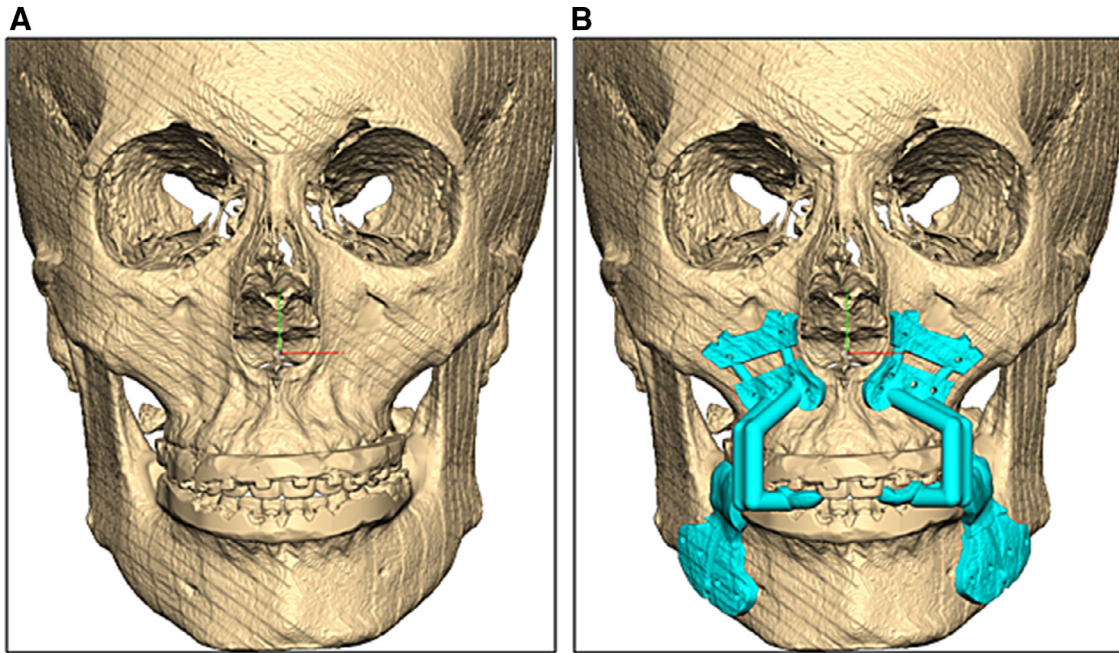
(A) CBCT images after virtual surgery. (B) Patient-customized osteotomy guides designed after virtual surgery (MegaGen, Seoul, Korea).
